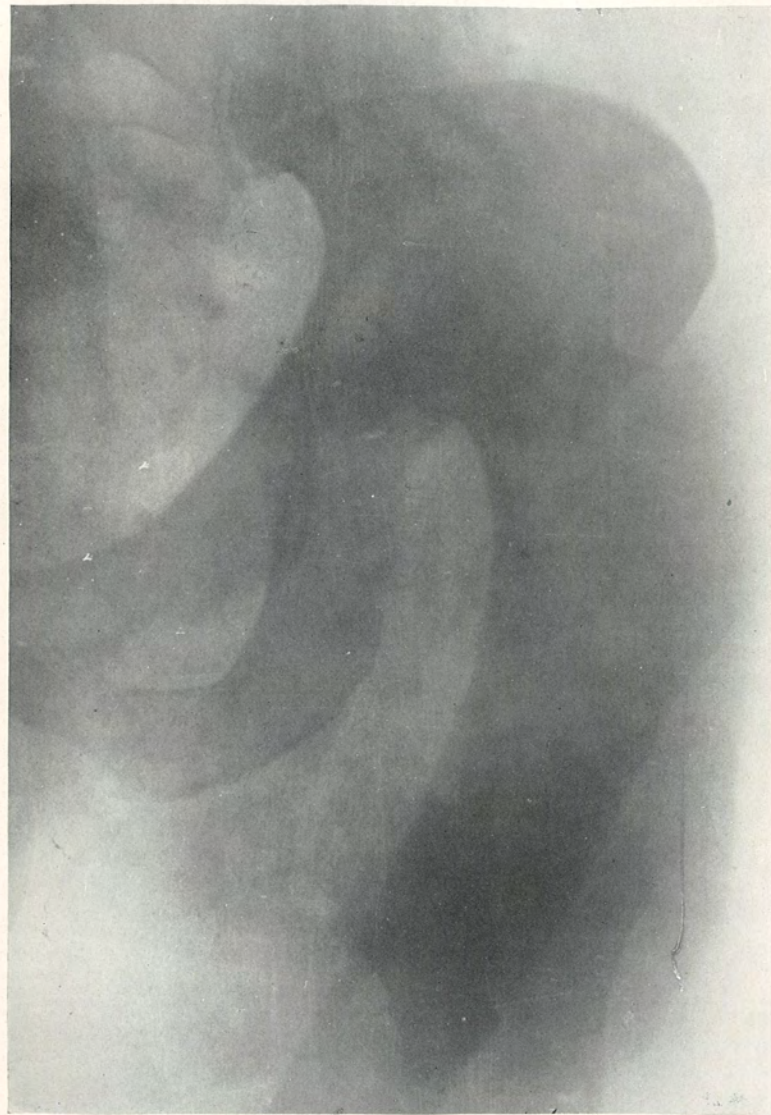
Case VII. X-ray No. 5243. Showing dislocation of right hip (posterior).
